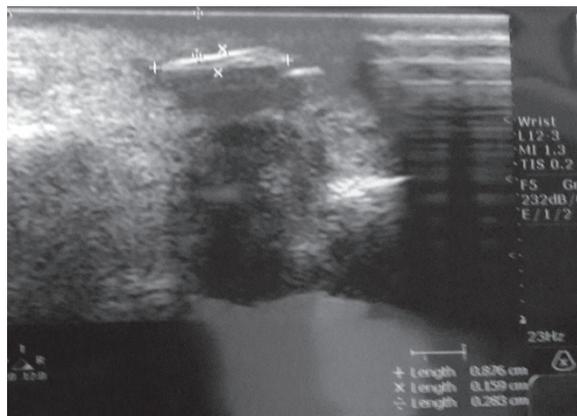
Ultrasonography of a patient showing foreign body in dorsum of hand
